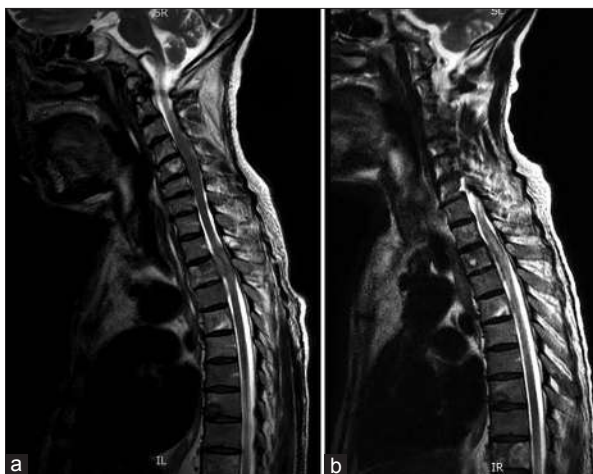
MRI T2W sagittal image showing (a) metastasis with cord compression (prostate) (b) Response to orchidectomy can often be dramatic as shown in the image on the right and may obviate the need for immediate surgery
